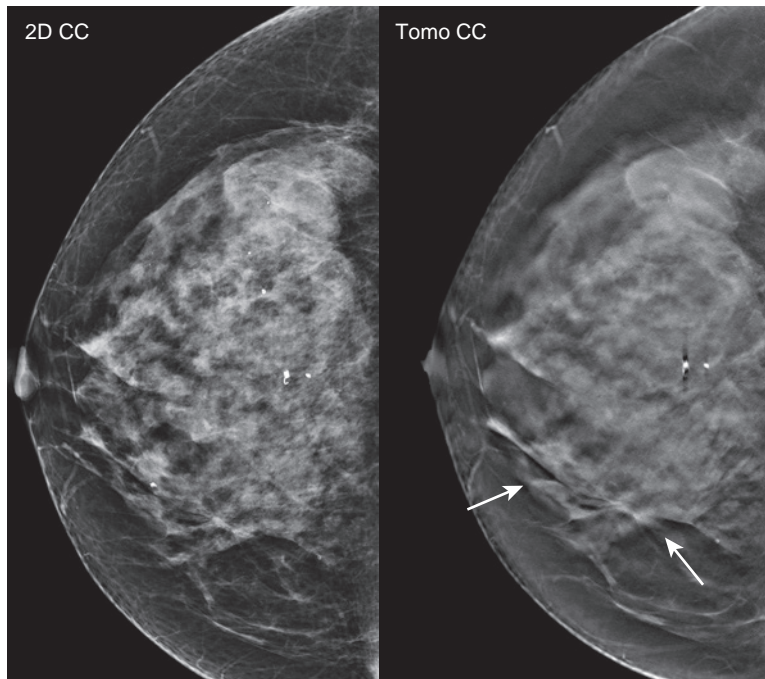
Postoperative scar seen only on tomosynthesis mimicking malignancy. Screening mammogram in a 67-year-old woman reveals an AD seen only on the CC tomosynthesis view in the inner right breast (*arrows*), best seen on a superiorly located tomosynthesis slice. This was a “new” mammographic finding, and recall was considered. Fortunately the screening mammogram was read online before the patient left the department. While the technologist was performing screening dense breast ultrasound, she noticed a corresponding very faint remote biopsy scar on the skin in the upper inner quadrant and no underlying sonographic abnormality. The patient had not previously reported this surgical history, and because the 2D mammogram was stable for many years, the AD and exam was interpreted as BI-RADS 2 and a diagnostic work-up was averted.
